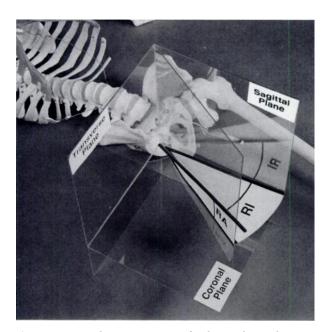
Visual representation of radiographic inclination and radiographic anteversion as outlined by Murray (38).
